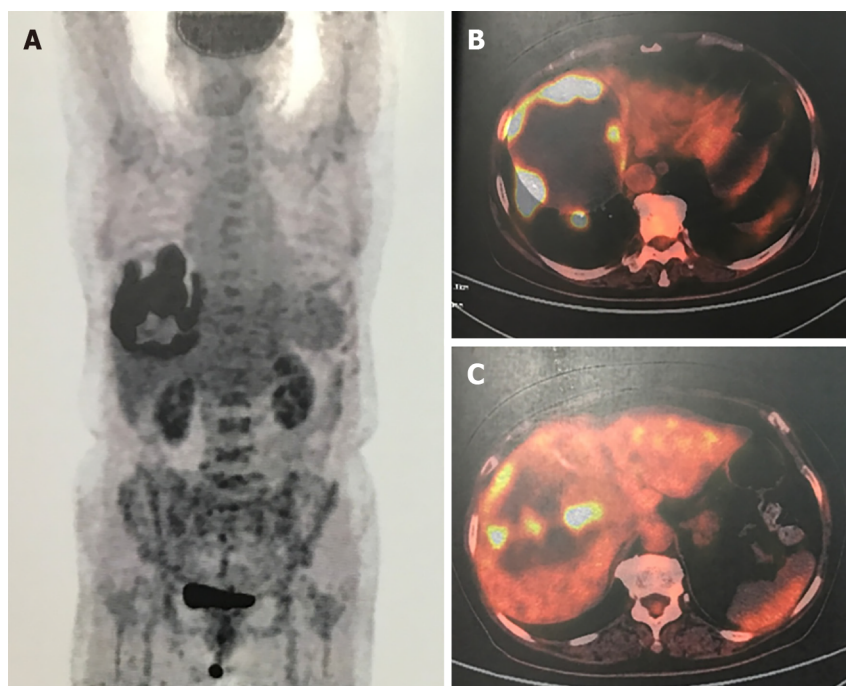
Positron emission tomography-computed tomography. A-C: Radioactive concentration of ^{18}F -fluorodeoxyglucose on the tumor rim, and no radioactive concentration was observed in other areas of the body.
